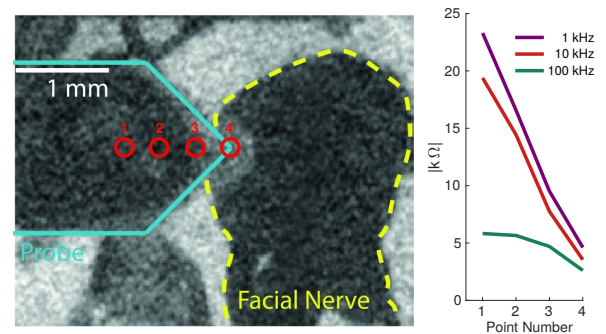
Post-operative μ CT slice (left) of the drill trajectory where red dots indicate the probe tip at points p1 ... p4. $|Z|$ (right) at three frequencies as a function of point number.
